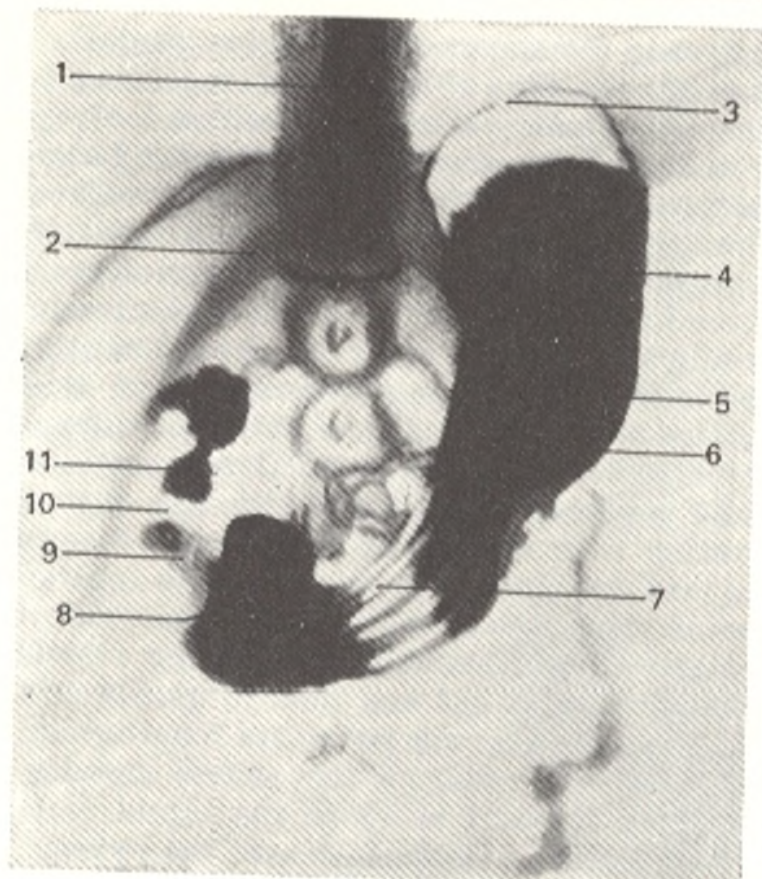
Radiograph of stomach.
